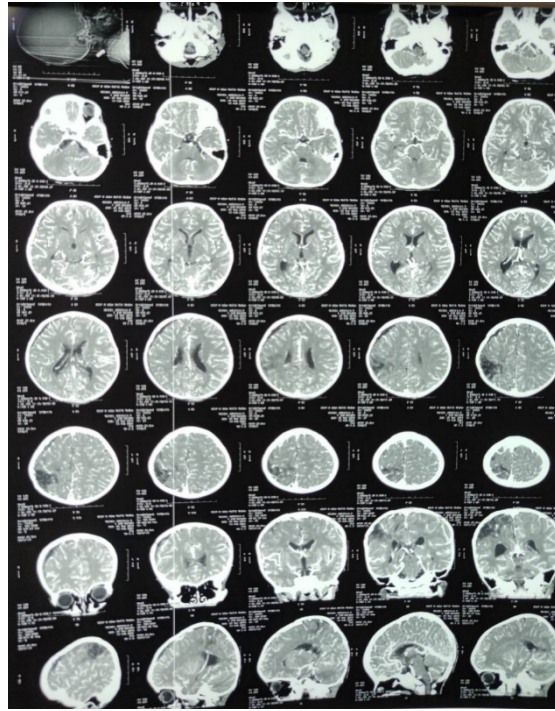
Head Contrast CT scan 6 weeks after continuing oral Antibiotic for 2 weeks
